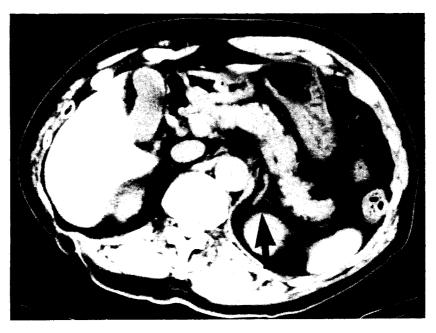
CT scan of the abdomen of a patient with unilateral adrenal medullary hyperplasia. Arrow indicates the enlarged adrenal gland.
